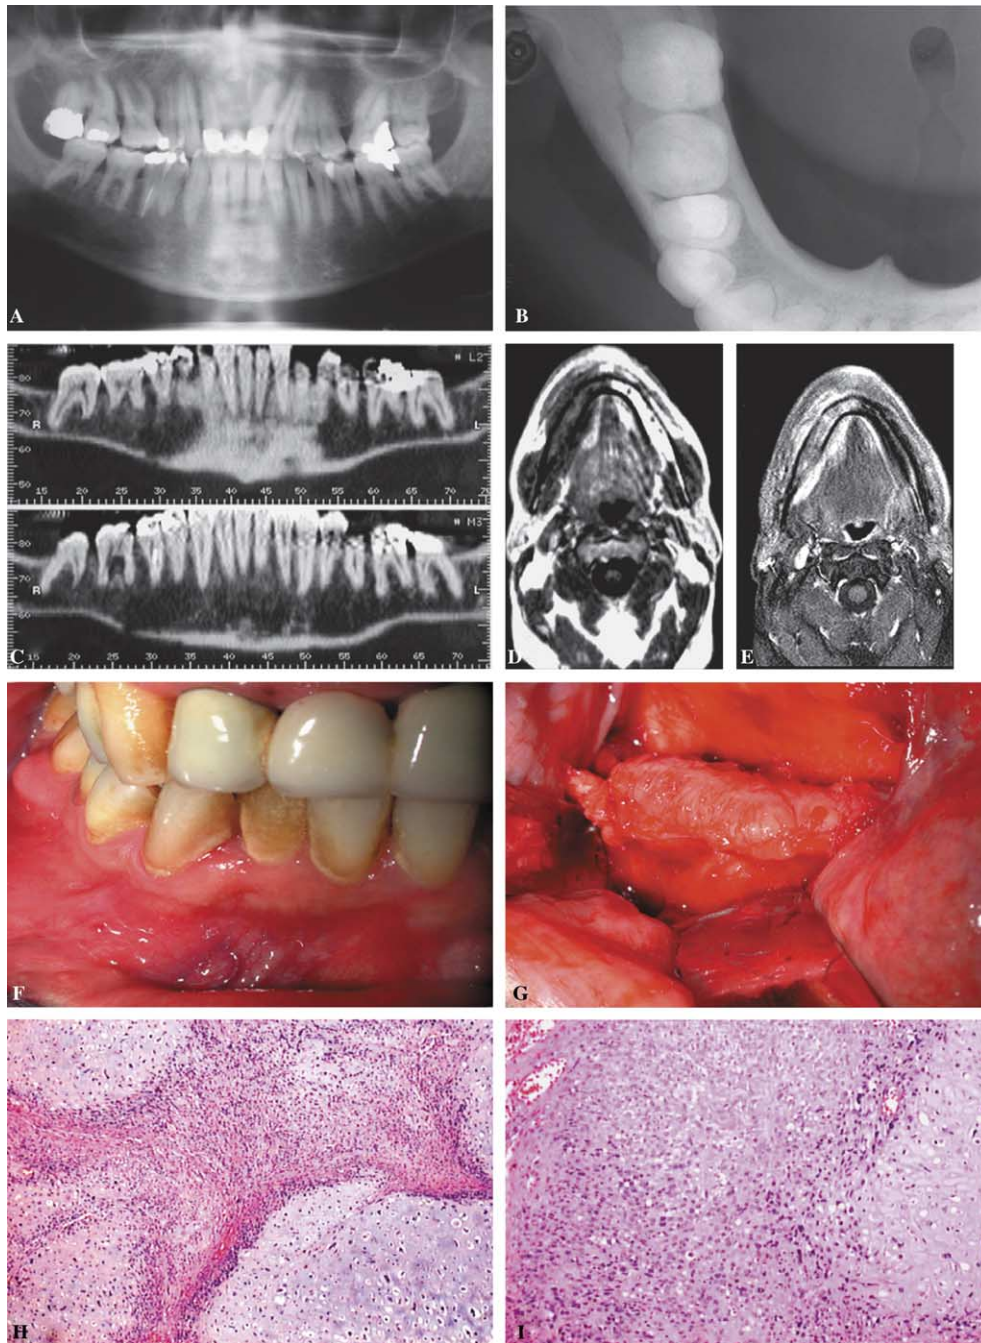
(A) Orthopantomographic exam revealing an area of osteolysis in the right mandibular body, particularly in the periapical region of 4.6, with shedding of the mesial root of 4.7. (B) Inferior occlusal X-rays showing apical and periodontal reduction of bone mineral density of 4.5 and 4.4 involving the right eminandibula and the roots of 4.6 and 4.7. (C) Dental CT Scan demonstrated limited interradicular osteolysis of 4.6, with reduction of bone density in the right horizontal branch. (D) and (E) Post contrast T1W STIR and T2 MRI demonstrating the extent of bone and soft tissue involvement. The lesion appears hypointense in T1 and hyperintense in T2 and shows contrast-enhancement. (F) Intraoral examination revealing a normal mucosa with congested areas. (G) Surgical examination showing a white-gray, translucent mass, adhering loosely to the bone and firmly to the periosteum. (H) High grade chondroblastic OS; chondroblastic activity with atypical osteosarcoma cells arranged in palisades and sometimes in vortices (EE 10X). (I) At higher magnification (EE 20X) small atypical osteoblasts with one or more nuclei in the context of dilated blood vessels and polymorphic chondroblastic proliferation are observed.
